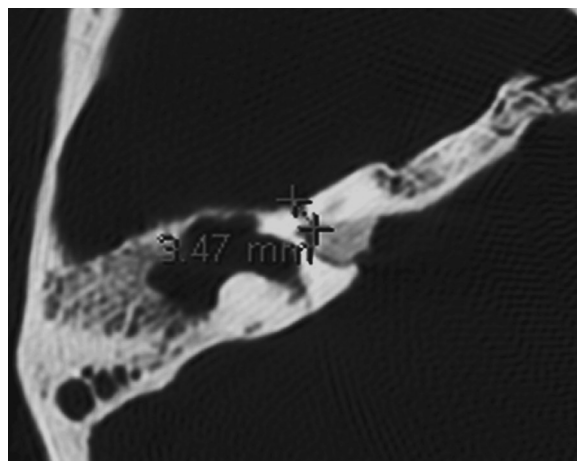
The length of the LS of the FN on the axial temporal bone HRCT scan.
